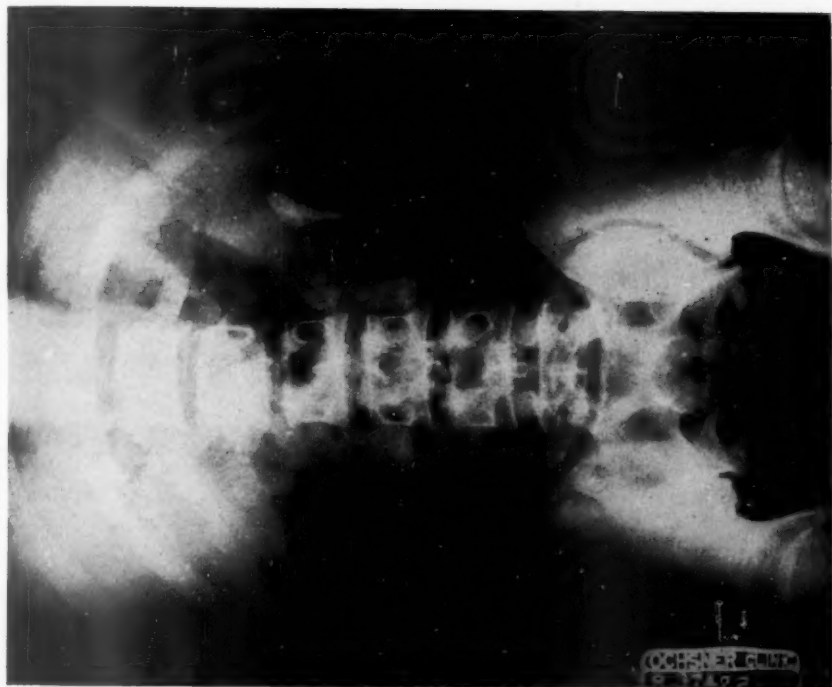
Plain roentgenogram on admission revealing calculus in left kidney.
